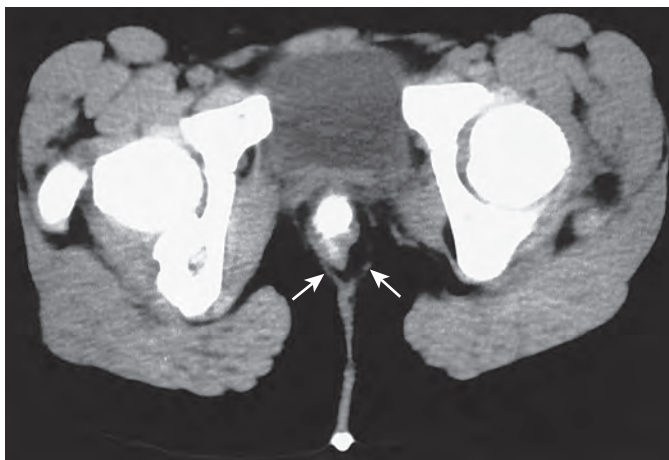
Imperforate anus: postoperative CT. For the postoperative evaluation of the sphincter muscle in an infant with imperforate anus, pelvic CT shows that the sphincter muscles (arrows) are extremely thin and underdeveloped.
